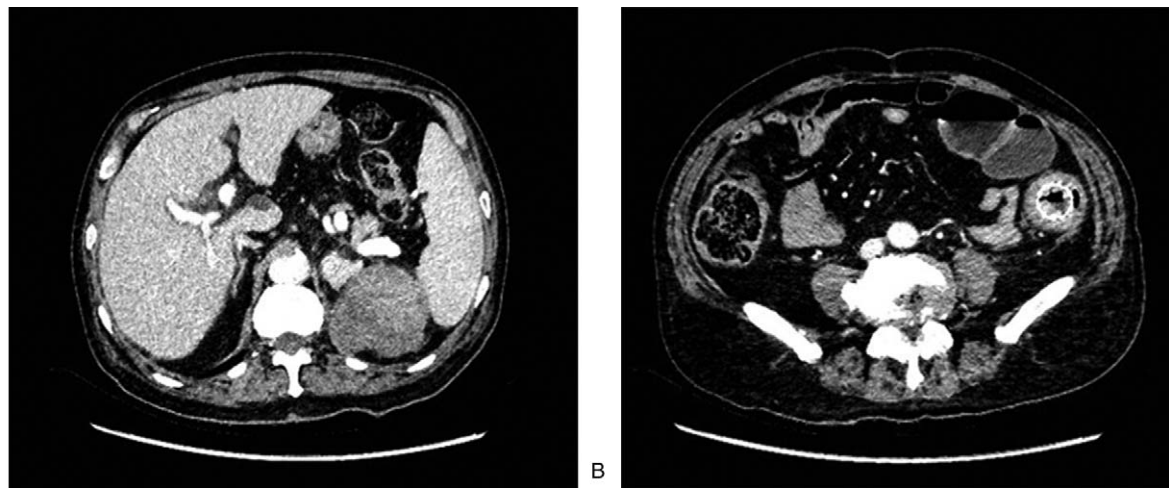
Neoplasms showed by contrast-enhanced CT. A, Neoplasms in left kidney and adrenal gland. B, A neoplasm in the lower part of the descending colon. CT=computed tomography.
